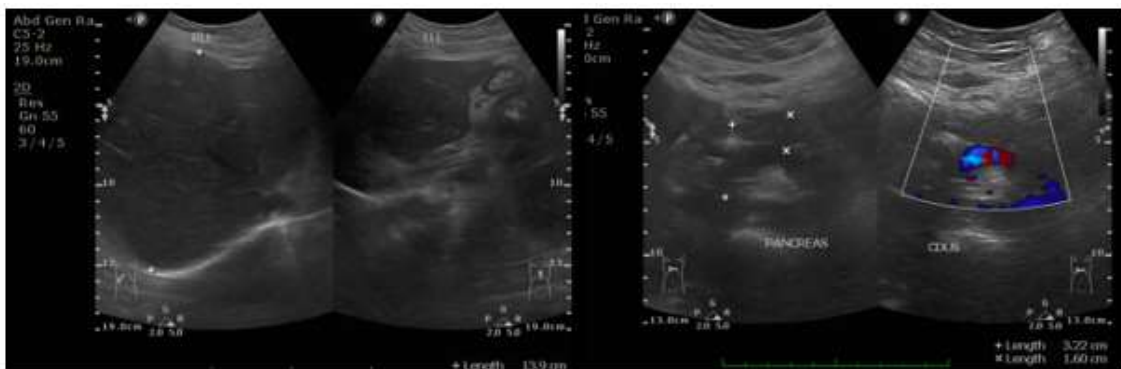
Liver in segments V, VI, VII, and VIII of the liver, Edematous pancreatitis (Abdomen ultrasonography, February 2023).
